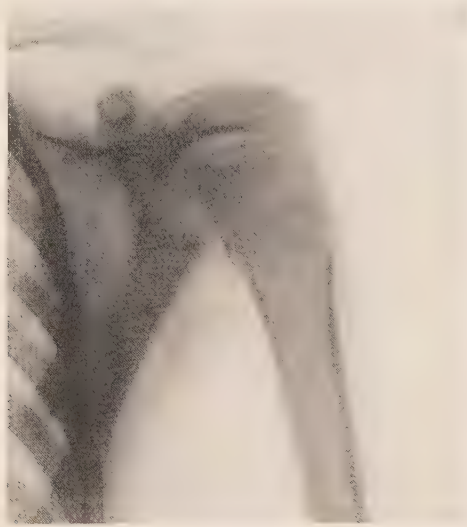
Impacted fracture of the surgical neck of the humerus. (Roentgenogram by Dr. G. C. Bird.)
